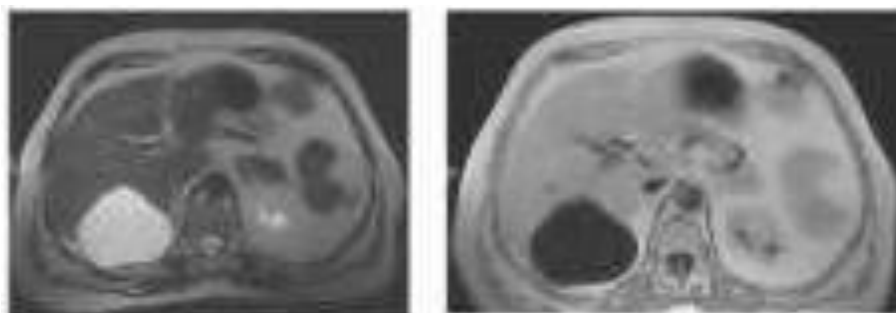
5. E, MRI T2, T2 VI - a) hypointense signal from liquid content in T2VI b) hypo-intense in T1VI (against the background of the introduction of 40.0 paramagnets Omniscan).
